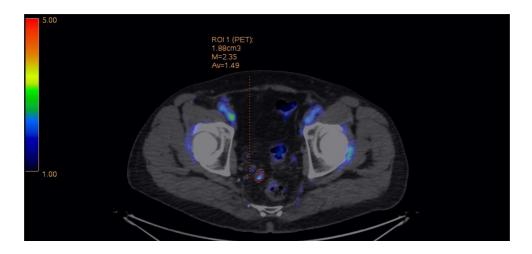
Further evaluation suggested by the haematologist consisted of a fluorodeoxyglucose positron emission tomographycomputed tomography scan revealing moderate uptake of the nodule.
